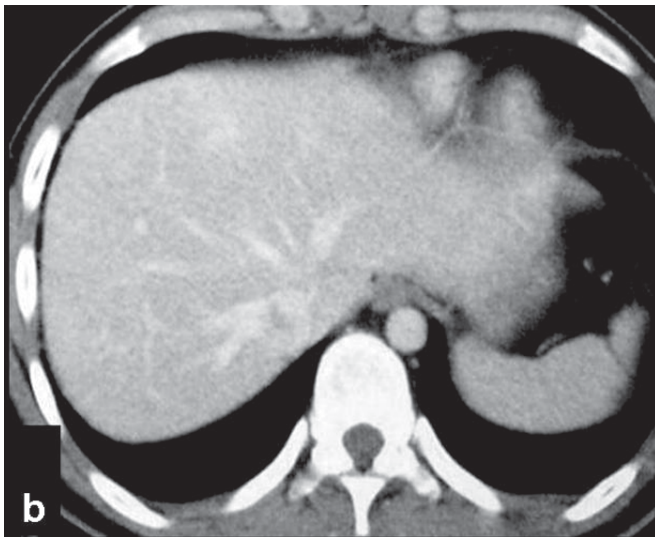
Venous phase (b) images in a patient with rapid venous washout suggestive of hypervascular metastases. Such hypervascular lesions can be missed if only a contrast-enhanced CT that is acquired in the venous phase is performed.
